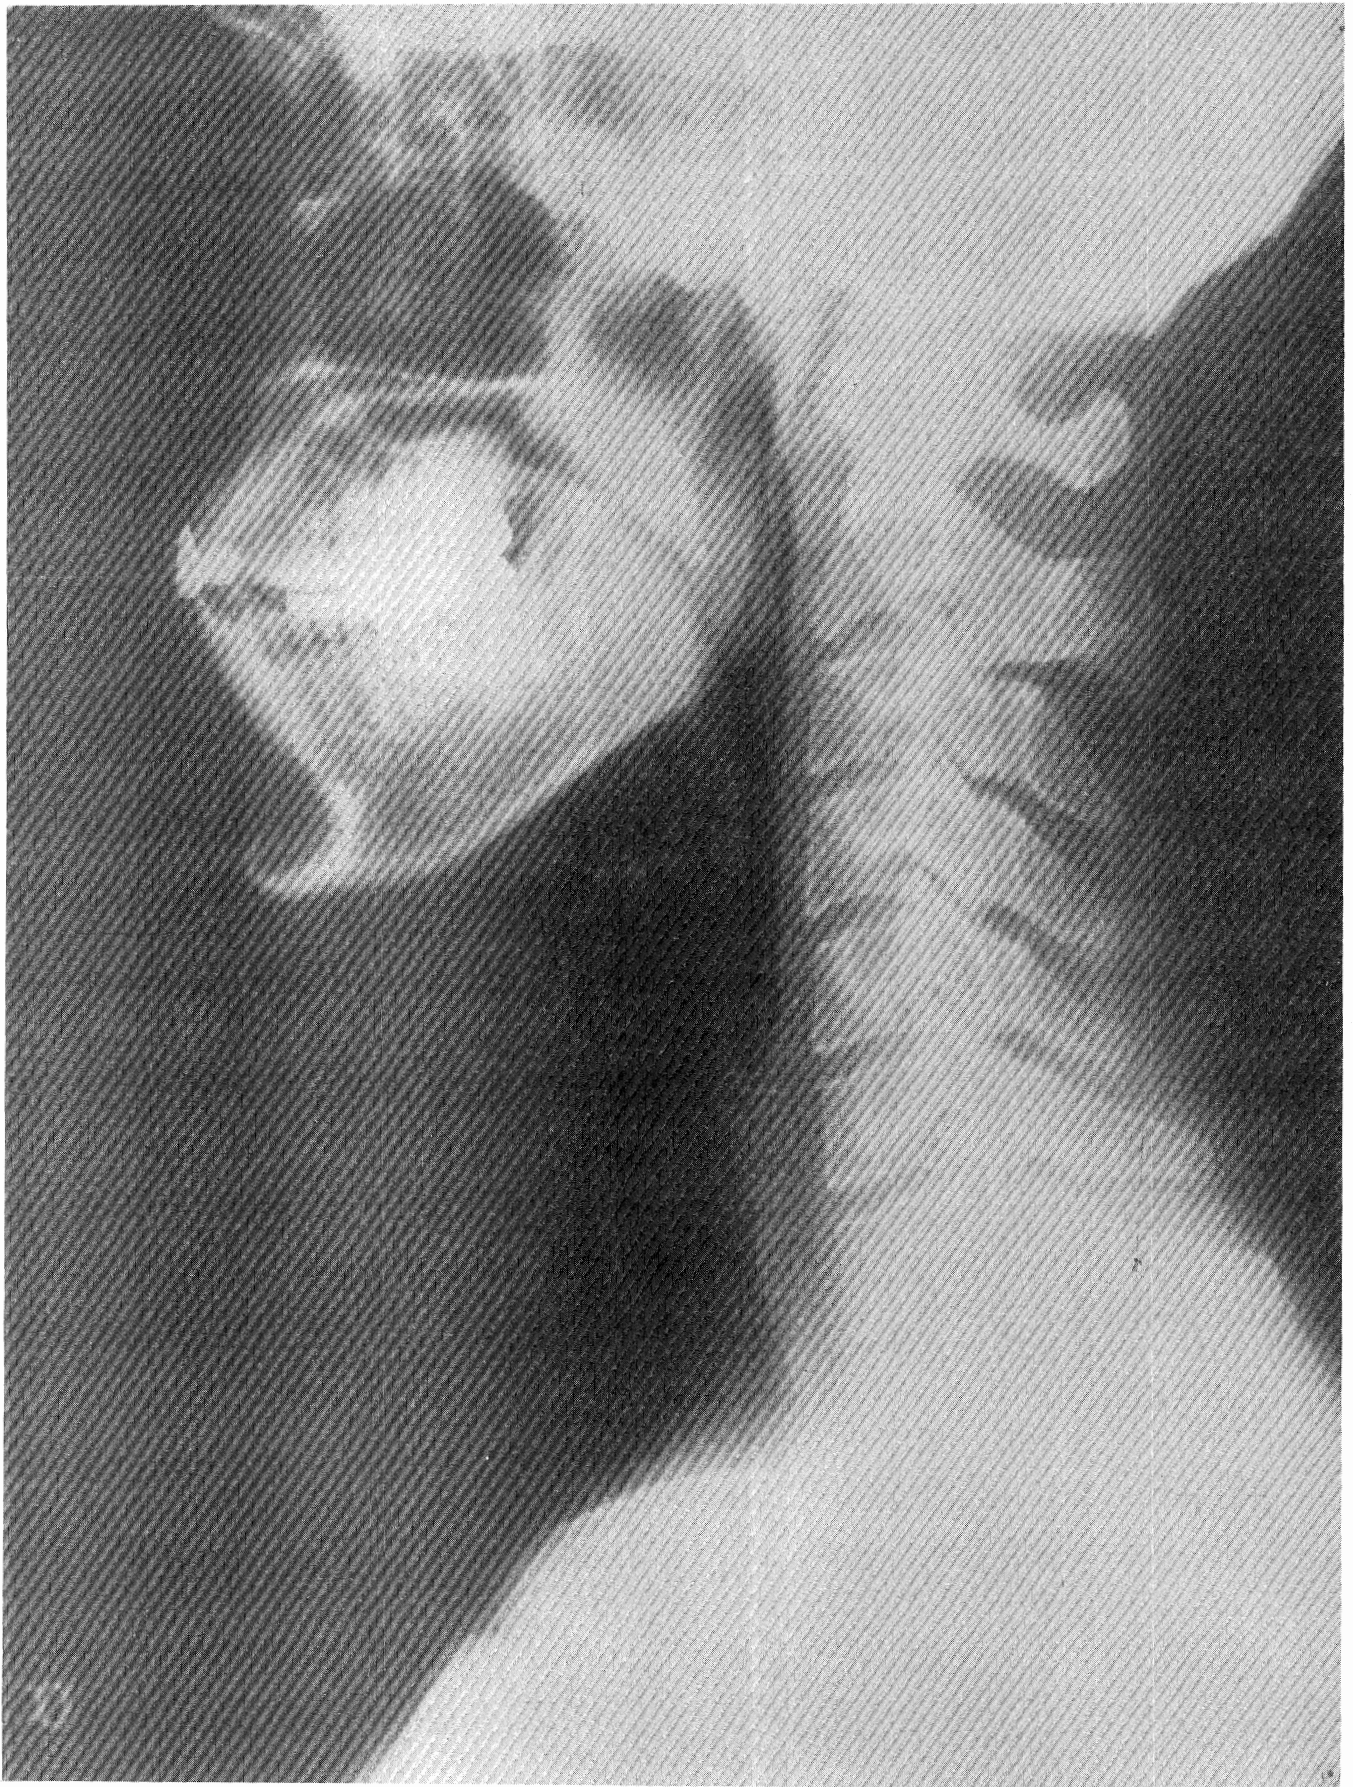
Cervical Radiograph, Right Lateral View, Normal Sitting Position.
